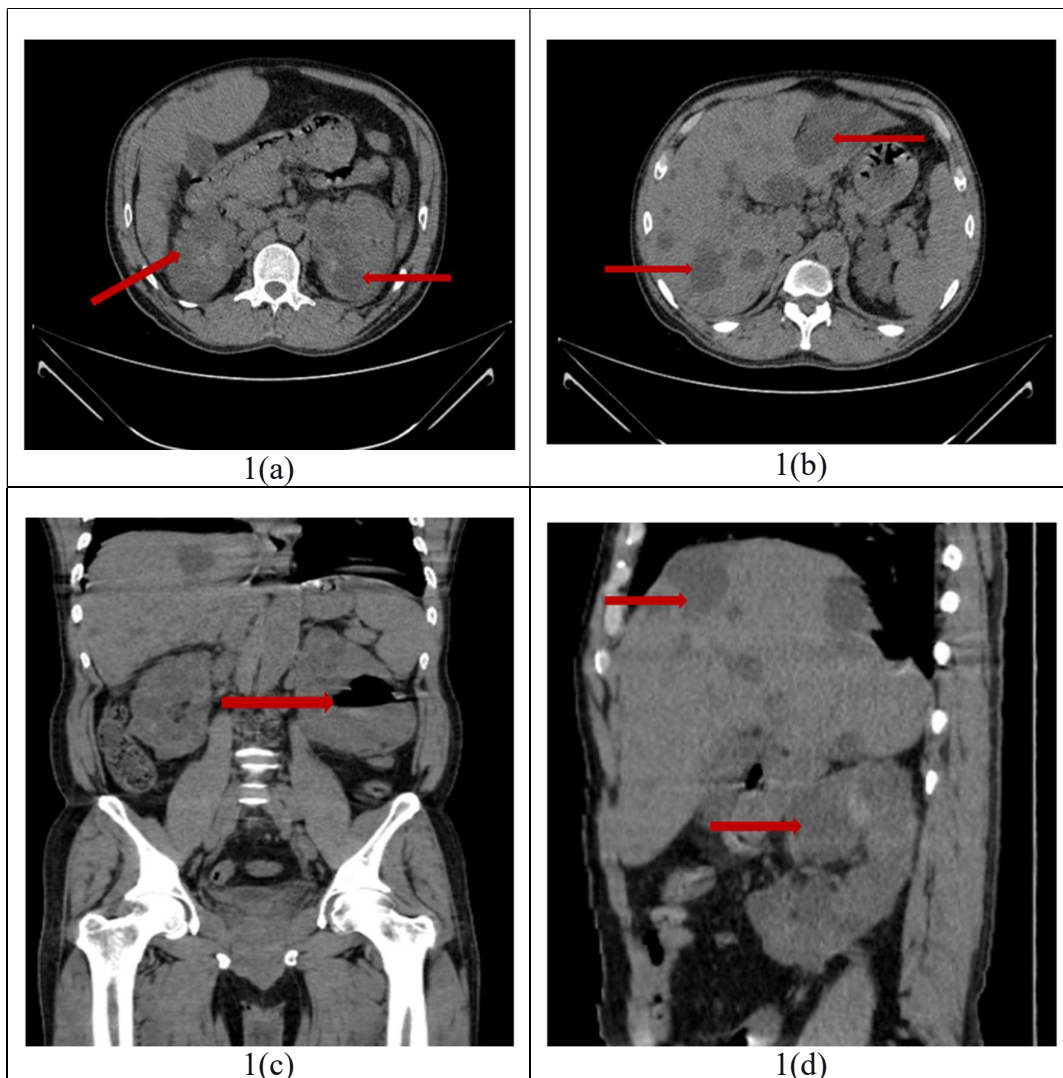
Computed tomography (CT) images of the abdomen and pelvis
